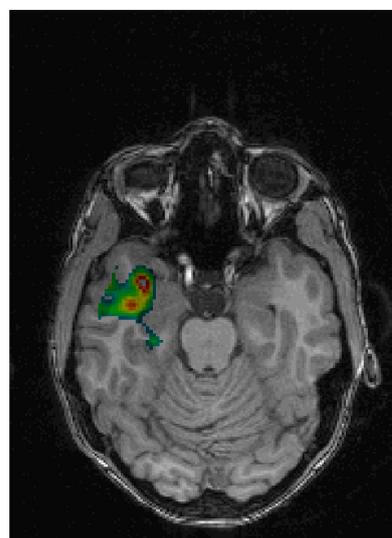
Example of a clearly visible active epileptic focus in the SISCOM image obtained by subtracting the ictal and interictal cerebral blood flow SPECT image, superimposed on the patient's own structural MRI.
